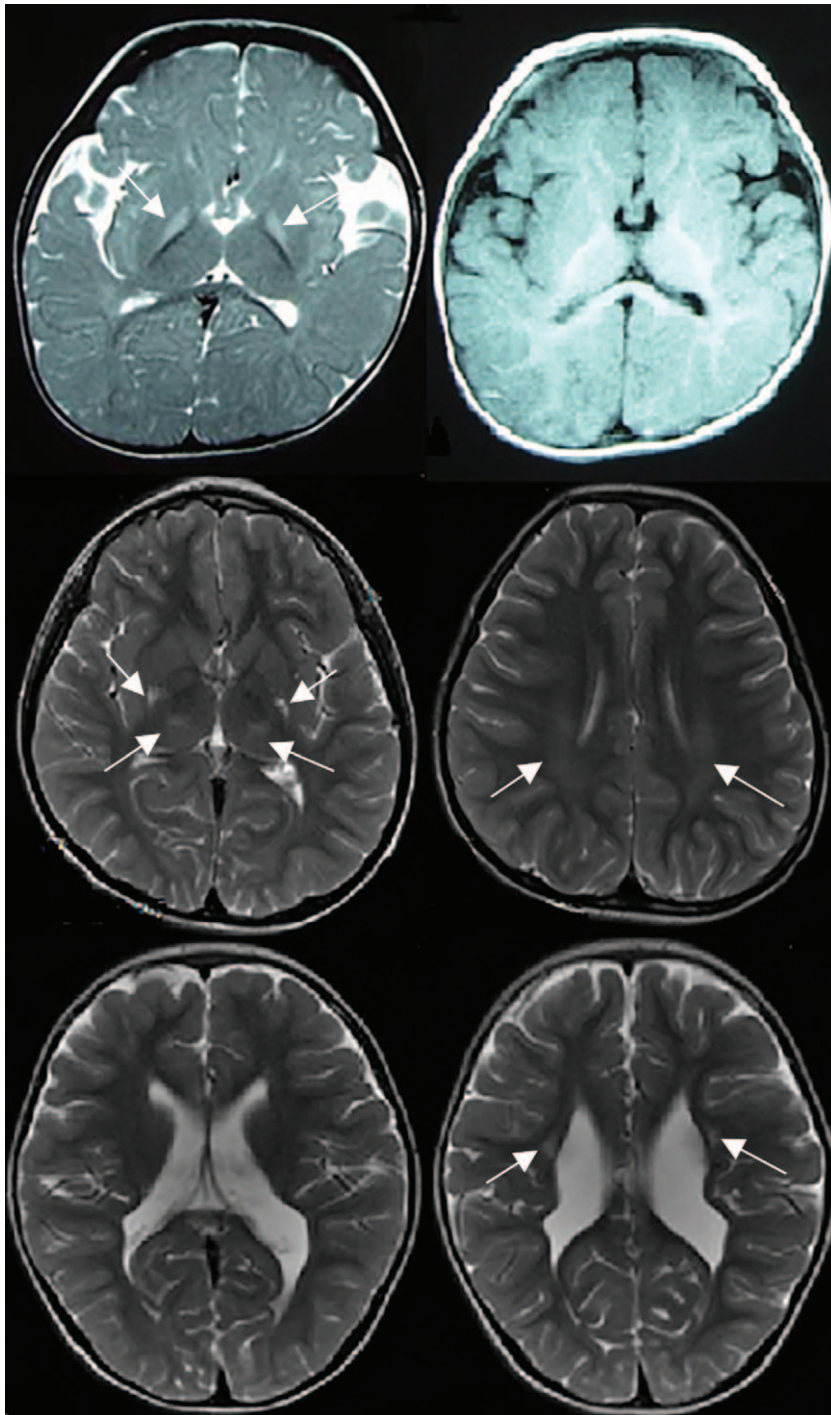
Upper: Axial MRI of bilateral basal ganglia lesions in a 19-month-old female with dystonic CP and a history of hyperbilirubinemia. Left: Axial T2-weighted image demonstrates bilateral, symmetric hyperintensity in the globus pallidus (arrows). Right: Axial T1-weighted image showed no signal-intensity abnormality in the globus pallidus. Middle: Axial MRI of basal ganglia/thalamus lesion combined with white matter lesion in a 8-year-old male with choreoathetotic CP and a history of profound HIE. Axial T2-weighted images showed putamen, thalamus, and paracentral white matter lesions (arrows). Lower: Axial MRI of white matter lesions in a 34-month-old female with mixed CP, 29⁺⁴ week gestation and a history of mild asphyxia. Axial T2-weighted image demonstrates periventricular leukomalacia, arrow indicates the periventricular gliosis.
